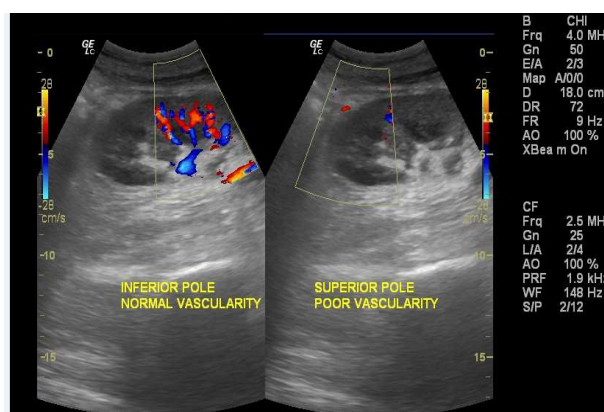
showing Doppler ultrasound scan with reduce perfusion of the superior pole.
